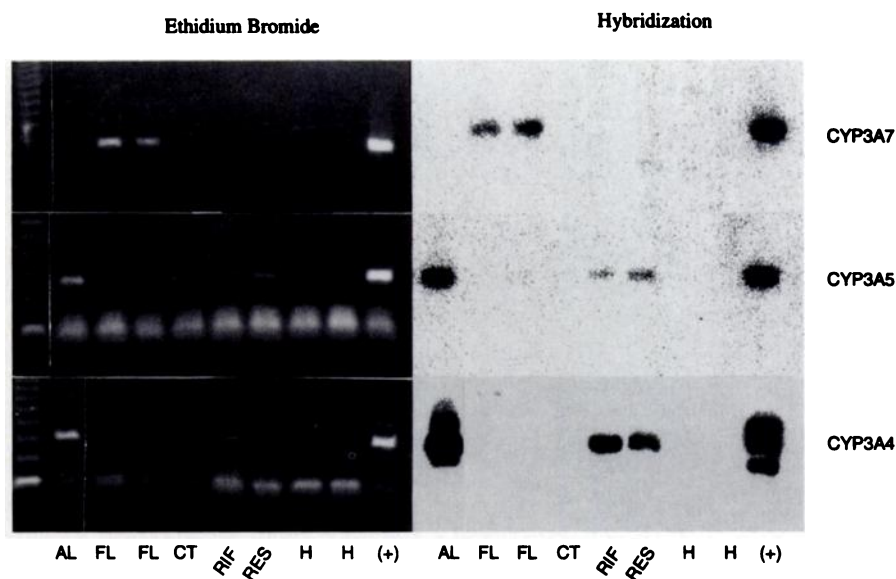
Amplification of CYP3A4 and CYP3A5 from LS180 cells. First-strand cDNA was synthesized from total RNA prepared from human adult liver (AL), human fetal liver (FL), or LS180/WT cells; untreated controls (CT); or cells treated with rifampicin (RIF) or reserpine (RES). First-strand cDNA was amplified using primers specific for each of the indicated CYP3A cDNAs. Specific positive controls (+) for the CYP3A7, CYP3A5, and CYP3A4 primer amplifications were the cloned cDNAs for CYP3A7, CYP3A5, and CYP3A4, respectively (see Materials and Methods). The negative PCR control was water (H). PCR product (40 μ l) was resolved on an agarose gel, visualized by ethidium bromide (left), and then Southern blotted to a Nytran membrane and hybridized with CYP3A4, CYP3A5, and CYP3A7 oligonucleotides (right) specific for sequences internal to the amplified PCR products (see Table 1).
